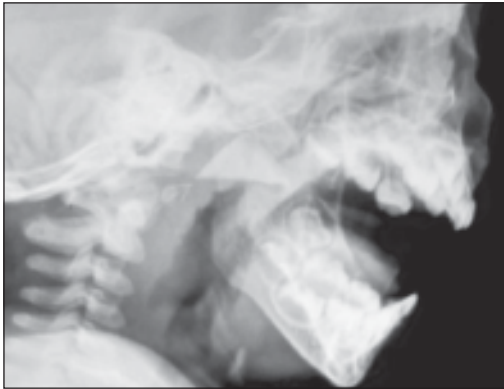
The X-ray of soft tissue pharynx and neck lateral view of the child showing the triangular radio-opaque foreign body lodged in the nasopharynx.*
